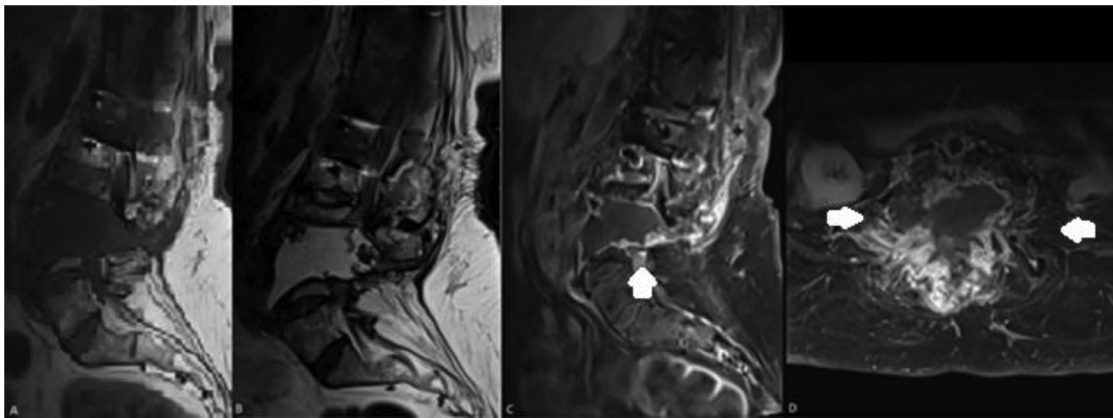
The MRI T1- and T2-weighted images (A, B) and images after contrast administration (C, D) show the extent of infection in the paravertebral tissue, with abscess formation in both psoas muscles as well as spinal empyema at the L2-L4 level (white arrows).
